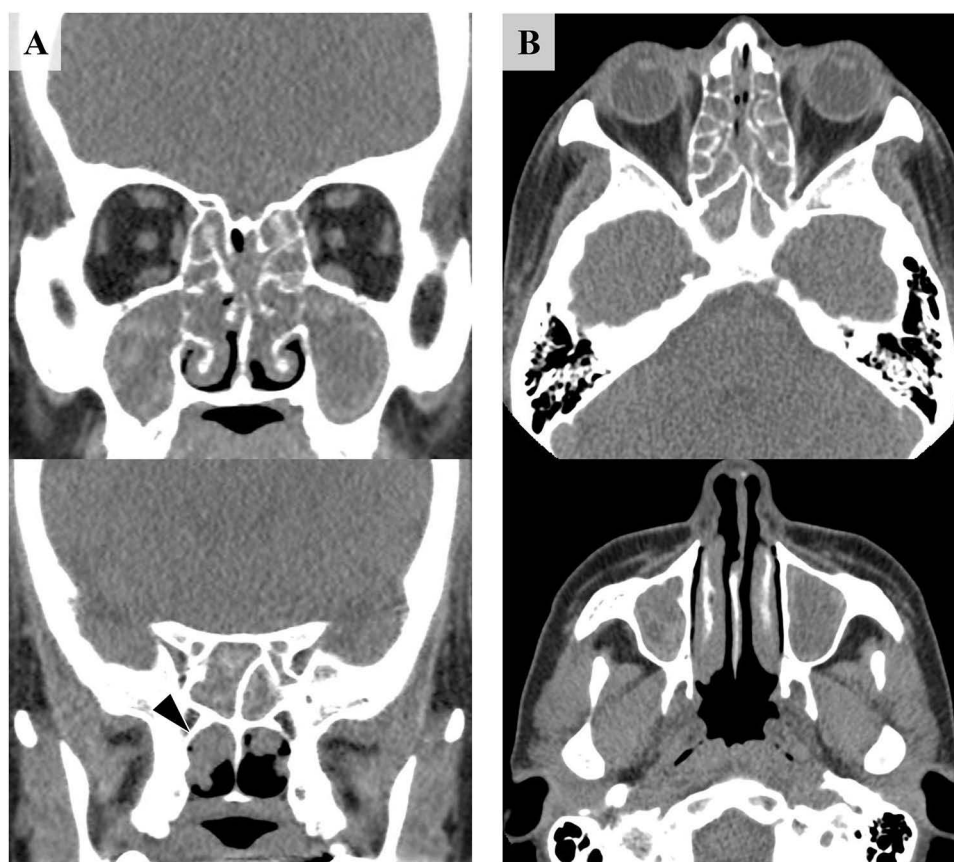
Computed tomography findings of severe eosinophilic rhinosinusitis. Coronal (A) and axial (B) computed tomography images showing diffuse mucosal thickening in bilateral nasal cavities, maxillary, ethmoid, and sphenoid sinuses with nasal polyps (arrow). The extensive mucosal disease is characteristic of severe eosinophilic rhinosinusitis before dupilumab administration.
